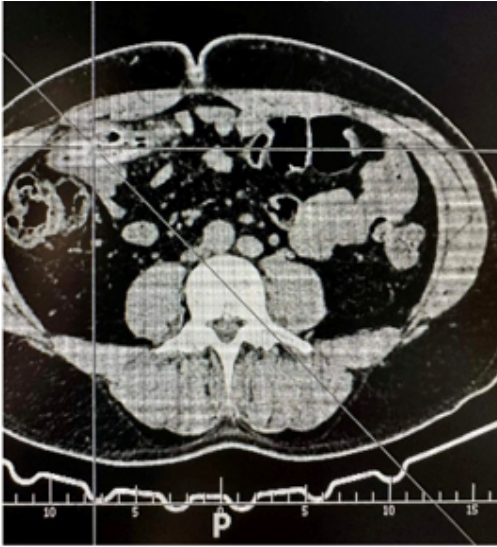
CT of the abdomen, cross-section; lines indicate the IGB.
